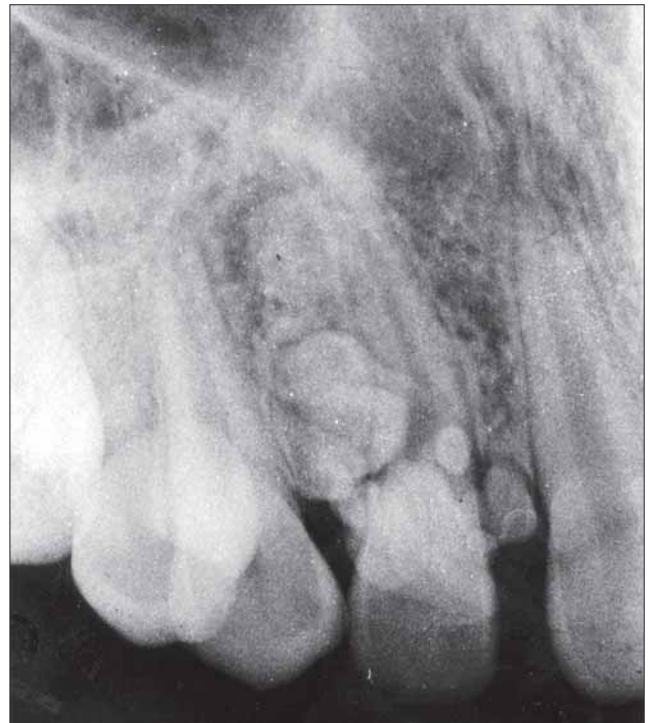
Case 2. Periapical radiograph showing the presence of a compound odontoma.
